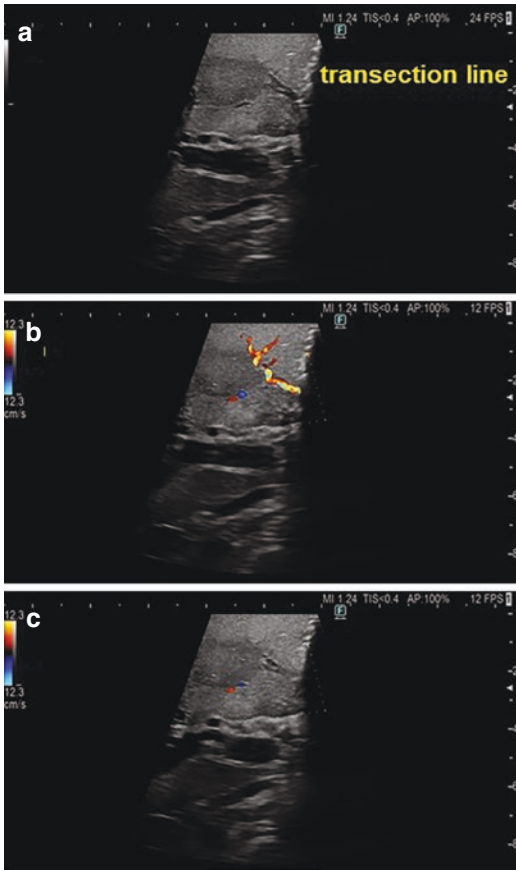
The line of transection along the umbilical ligament is checked by IOUS (a). The correct isolation of P4b is checked by the color Doppler: the portal flow to S4b is well documented (b). After pulling the tape, the consequent stop of the portal flow at color Doppler is well visible (c)
